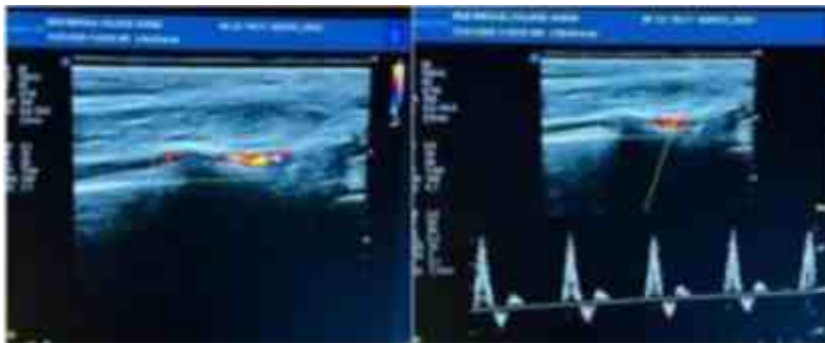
Same above patient (A) Wall thickening along Posterior Tibial Artery (PTA) with aliasing flow on Color Doppler, (B) showing normal triphasic waveform on spectral Doppler.
